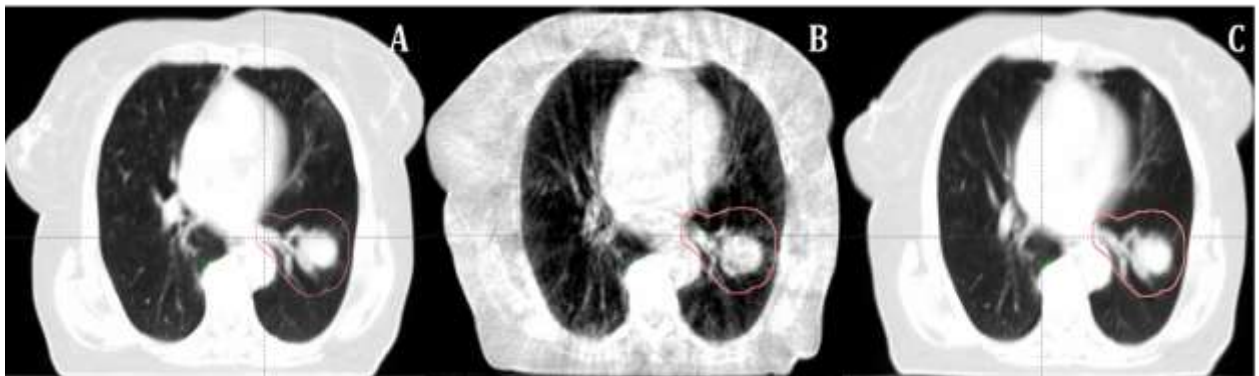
Planning CT image (A), cone beam computerised tomography (CBCT) image (B) and a synthetic CT image produced within the Velocity software (C).
